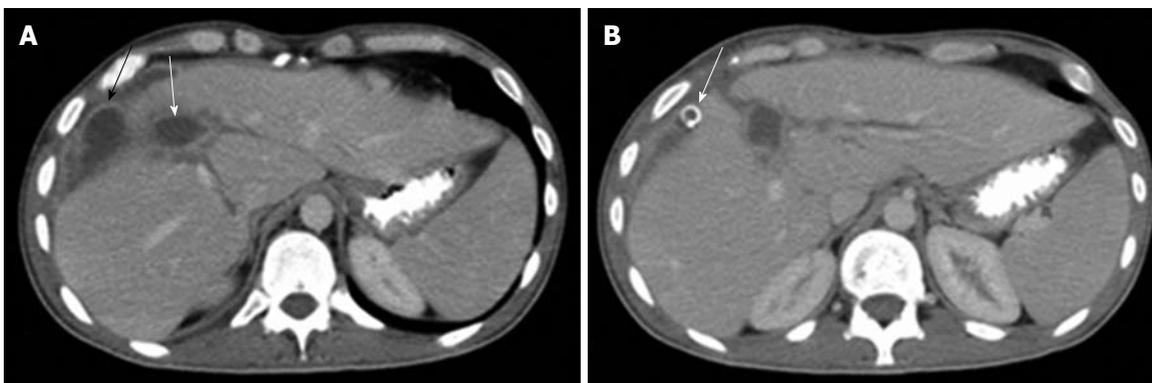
A case of acute cholecystitis with pericholecystic abscess. A: Computed tomography (CT) scan shows a pericholecystic abscess (black arrow) adjacent to acutely inflamed gallbladder (white arrow); B: Follow up after CT-guided drainage of the pericholecystic abscess shows marked resolution of the abscess with drainage tube seen within (arrow).
